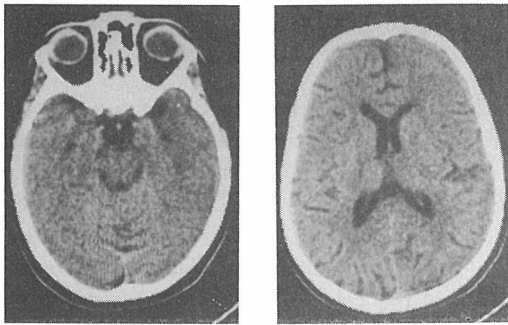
CT scans of Case No. 1; 39 months after therapy, when β -HCG in the serum was found to be elevated.
